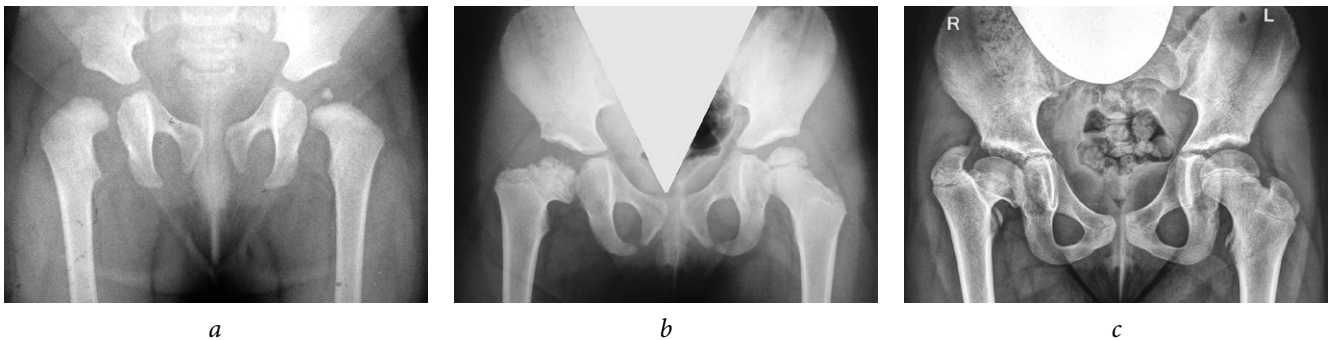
Radiographs of patient Sh. at the ages of 1 year, 2 months (a), 3 years, 9 months (b), and 11 years (c). Formation of multiplanar deformity of the proximal femur with a high position of the greater trochanter after avascular necrosis of the femoral head (on the right, Kalamchi and MacEwen class IV; on the left, Kalamchi and MacEwen class II). The patient had a history of conservative treatment for congenital bilateral dislocation of the hip
